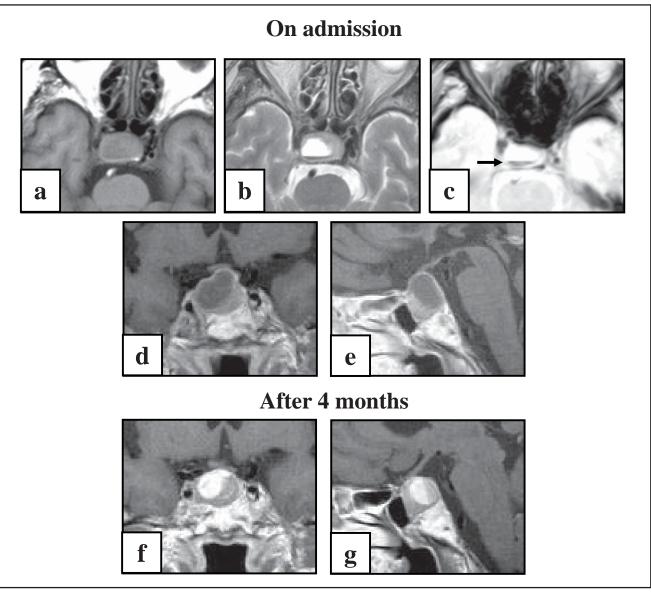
Pituitary MRI. a, b, Plain images on admission. T1- (a), T2- (b), and T2*- (c) weighted axial images are shown. Marked low-intensity area (arrow) indicates intratumoral hemorrhage. d-g, Gadolinium-enhanced T1-weighted images. The MRIs were taken on admission (d, e) and after 4 months (f, g).
